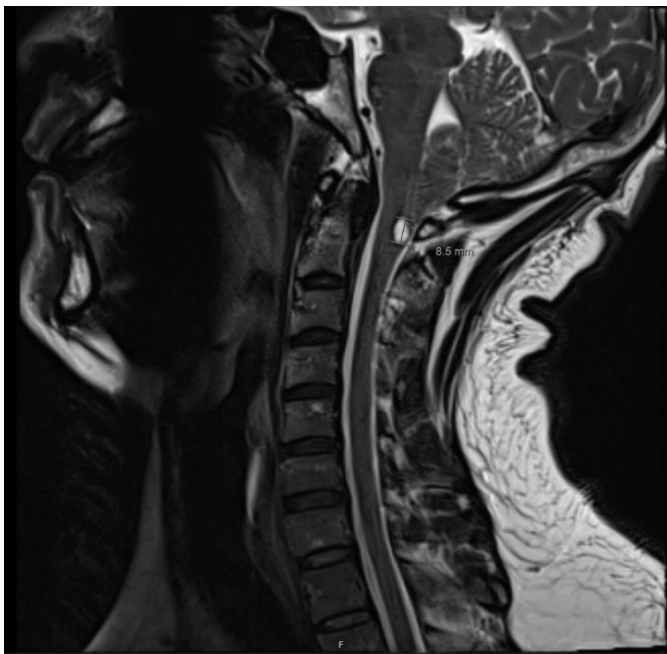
MR C-spine T2-weighted sagittal view measuring rostral-caudal dimension of the posterior cervical cord syrinx at approximately 9 mm. The pointing cerebellar tonsils for Chiari I malformation can also be appreciated here.
